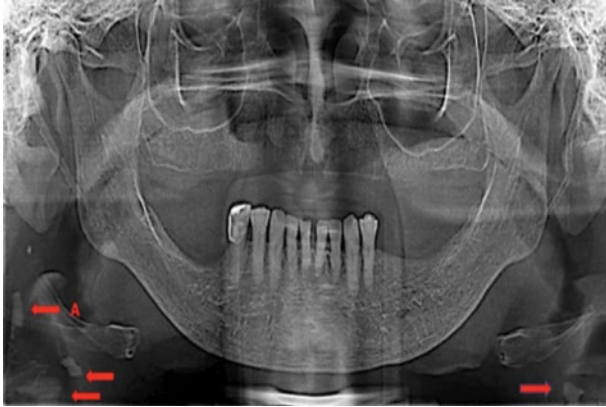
Multiple irregular radiopacities observed in the panoramic radiograph.
